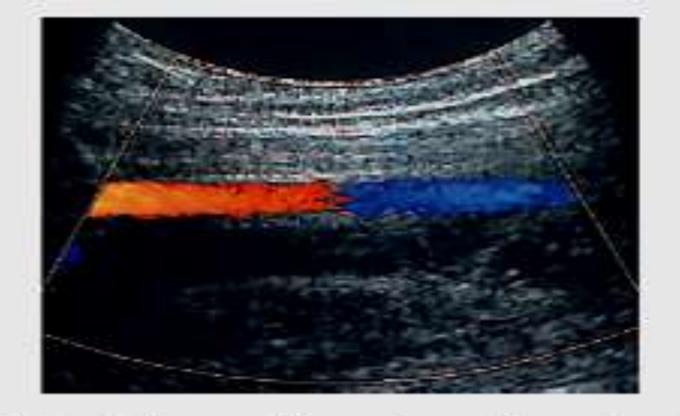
As the scan lines of a curvilinear transducer diverge, the angle between the straight vessel and the beam will change. This will lead to a change in the detected velocity relative to the ultrasound beam (Doppler frequency), altering the color displayed. No flow is displayed in the center of the image, where the flow is at right angles to the beam.
